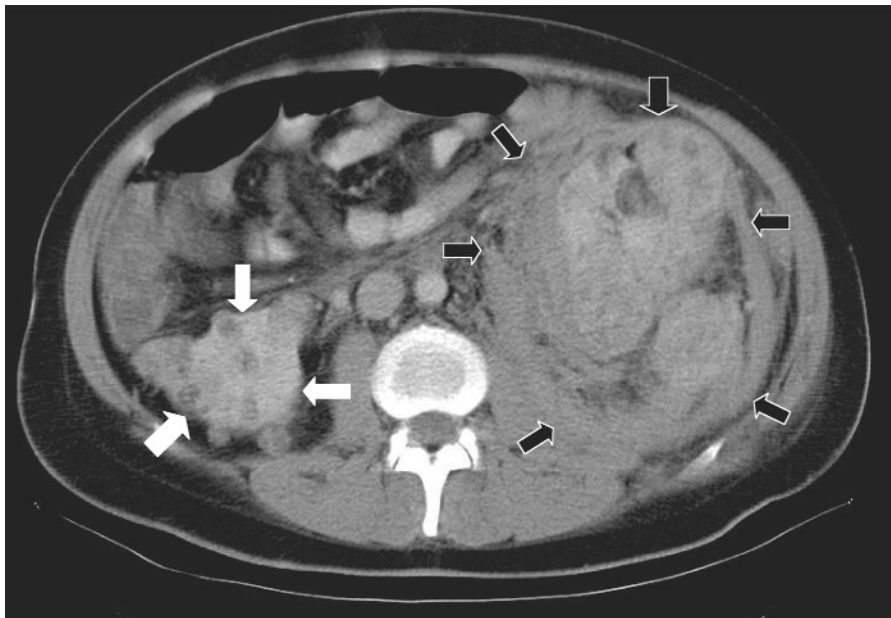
Retroperitoneal hemorrhage from angiomyolipoma, abdominal computed tomographic scan. *Black arrows* show the left kidney with infiltrating angiomyolipoma and surrounded by blood delimited by Gerota's fascia. *White arrows* show the right kidney with multiple small angiomyolipomas.
